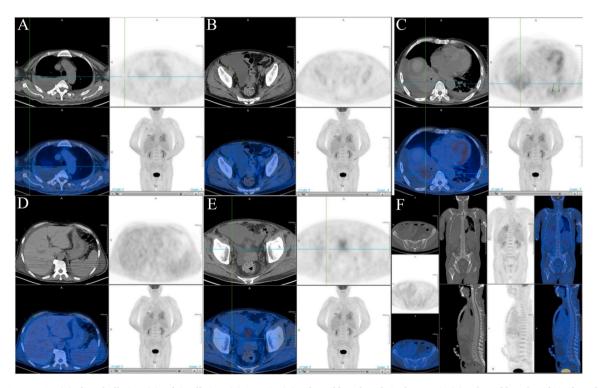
PET/CT. (A) Pleural effusion. (B) Pelvic effusion. (C) Anemia. (D) Enlarged lymph node in the armpit. (E) Enlarged lymph node in the pelvic wall. (F) Increased glucose metabolism in systemic bone marrow.
